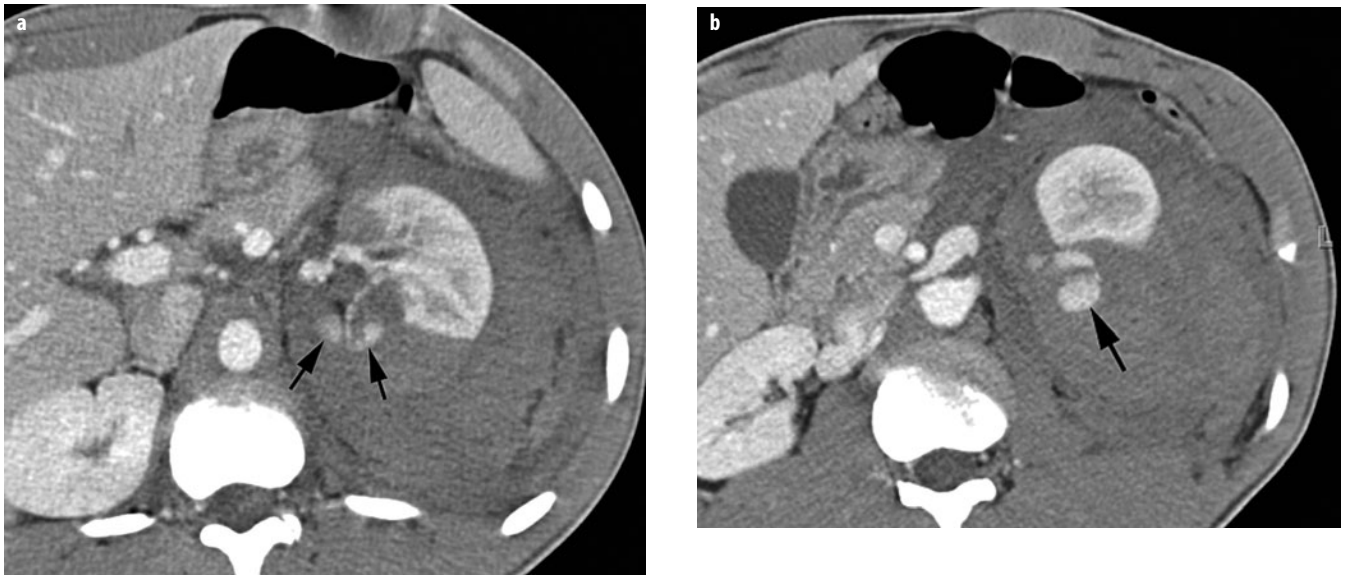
a, b. Deep (grade III) renal laceration with active extravasation. a, b Transaxial computed tomography (CT) images show a deep laceration of the left kidney that extends to the renal hilum. *Arrows (a, b)* indicate active extravasation. A large hematoma surrounds the kidney and displaces it anteriorly
